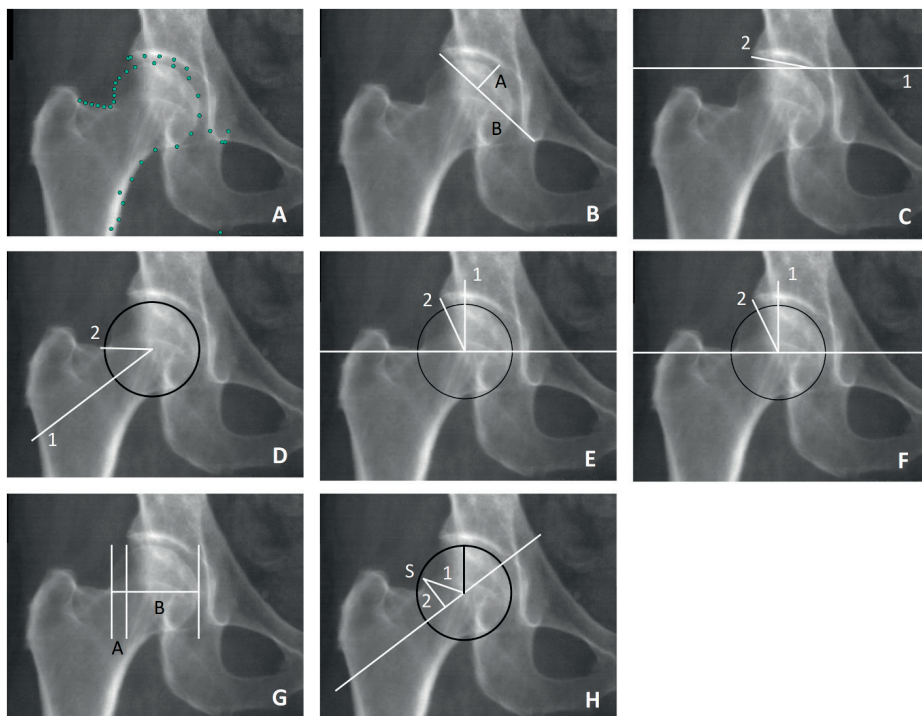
Example of landmark points and hip morphology measurements on a dual-energy x-ray absorptiometry (DXA) image. A: Overview of landmark points, 38 landmark points used to determine hip morphology measurements automatically. B: The acetabular depth-width ratio (ADR), $ADR = (A/B) \times 1000$, is the ratio between the acetabular depth (A), measured from the most medial point of the sourcil to line B, and the acetabular width (B), measured from the most lateral bony point of the acetabulum to the most caudal point of the teardrop. C: The modified acetabular index (mAI) is the angle between the horizontal reference line of the pelvis (HRLP) (line 1) and the line connecting the most lateral bony point of the acetabulum and the most medial point of the sourcil (line 2). D: The alpha angle (AA) is the angle between the femoral neck axis (line 1) and a line through the femoral head center and the alpha point (line 2). E: The Wiberg center edge angle (WCEA) is the angle between line 1, perpendicular to the HRLP, and line 2 through the femoral head center and the most lateral part of the acetabular sourcil. F: The lateral center edge angle (LCEA) is the angle between line 1, perpendicular to the HRLP, and line 2 through the femoral head center and the most lateral bony part of the acetabulum. G: The extrusion index (EI), $EI = A/(A+B) \times 100\%$, is the ratio between the uncovered part of the femoral head (A) and the width of the femoral head (A+B). H: The triangular index ratio (TIR) is the ratio between the radius of the femoral head and the length of line 1, the line connecting the intersection point (point S) of the cortex of the femoral head and line 2 and the femoral head center.
